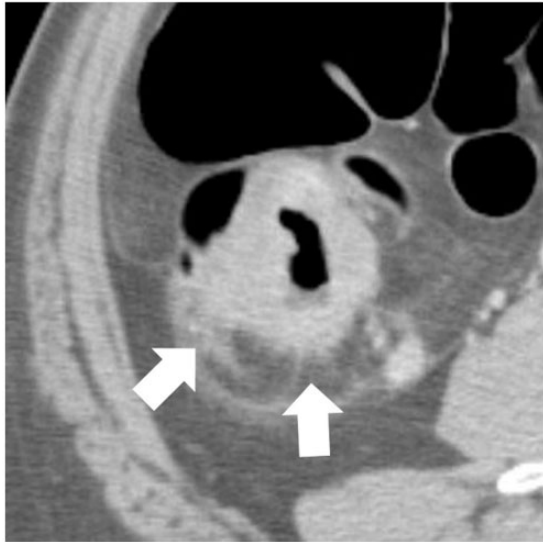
CT image of a 70-year-old man with ascending colon cancer whose longitudinal length was 42 mm. An axial CT image revealed that the circumferential proportion of the tumor was $\geq 75\%$, and pericolic fat stranding was identified around the lesion (arrow). Pathological diagnosis of depth of invasion was T4.
